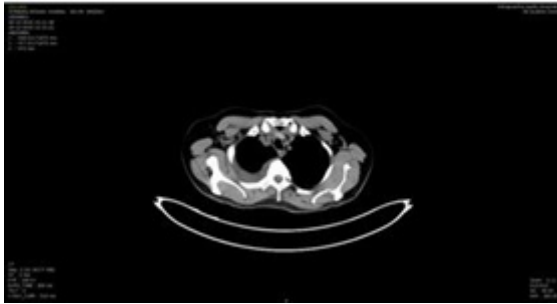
CT image of thorax (mediastinal window).
